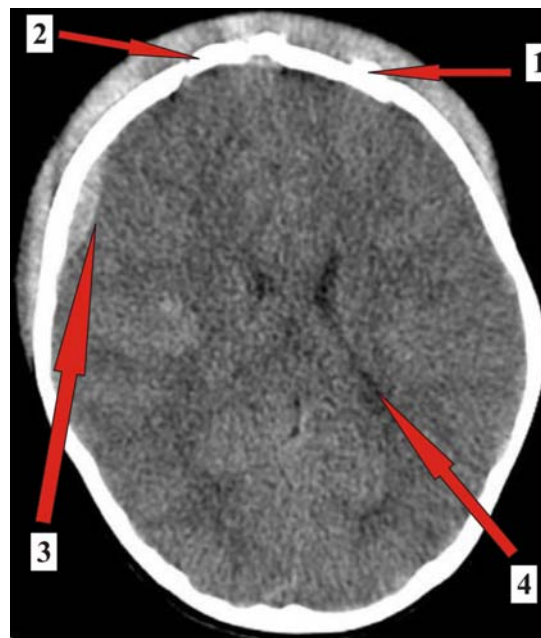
(a): CT scan showing various lesions viz - diffuse hyperdense scalp swelling (1), bifrontal fracture (2), right frontal extradural hematoma (3) and brain oedema (4).
